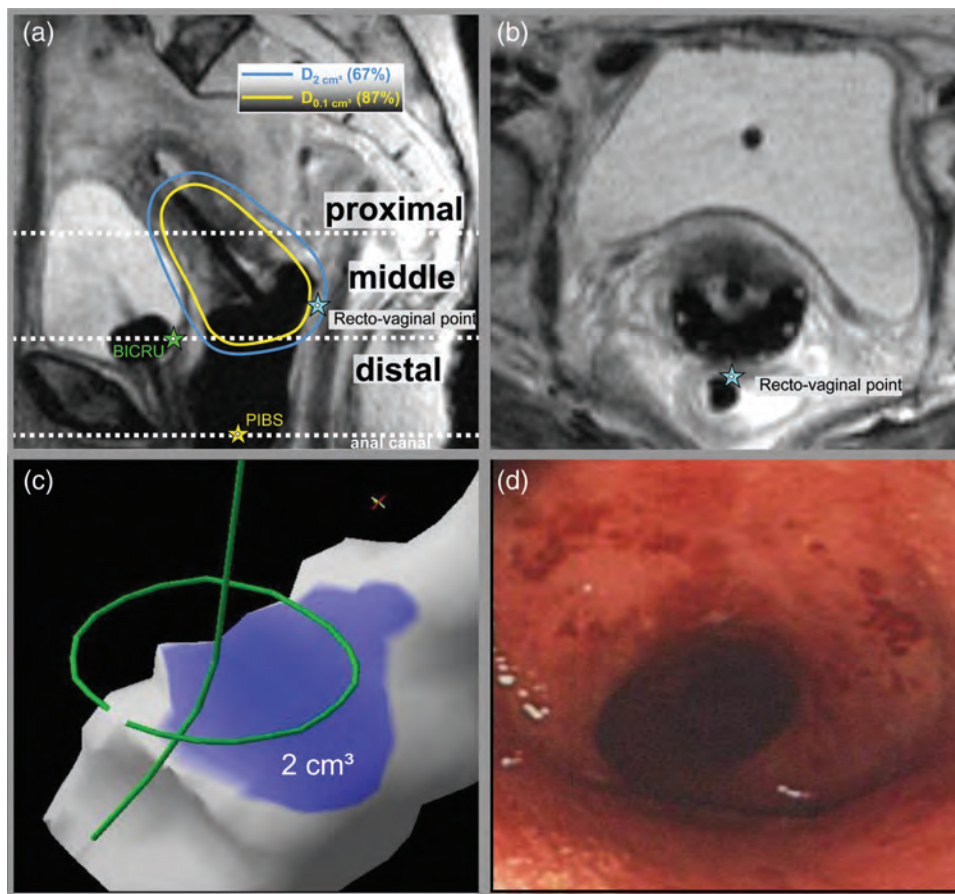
MRI sagittal and transversal views with utero-vaginal applicator in place and probe in the rectum with three transverse lines, indicating the distal, middle, and proximal third of the rectum (a) and the ICRU recto-vaginal point (RVICRU, blue star in a and b). Lower line is at the level of the pelvic diaphragm, which is indicated by the PIBS (yellow star) and also shows the beginning of the anal canal (see Figure 6.4). The highest absorbed dose is at the level of the vaginal sources above the middle line in the mid-rectum. The 2 cm^3 rectal volume is shown on the anterior wall (c). The $D_{2\text{cm}^3}$ and the $D_{0.1\text{cm}^3}$ for the rectum and the corresponding isodose lines (67%/87% of the prescribed absorbed dose) are shown and correspond to 71 and 103 Gy EQD₂₃, respectively (a) (see Section 8.4.1; compare examples in the Appendix). Endoscopic images of multiple teleangiectasia/petechiae related to the anterior wall 2 cm^3 volume after 18 months (d). Note also the bladder ICRU reference point (BICRU, green star) (modified from Georg *et al.*, 2009).
